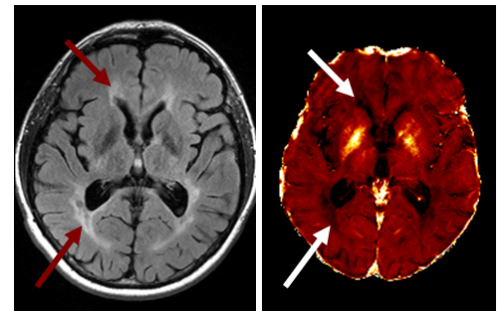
FLAIR image (left) and corresponding R2* map (right) of a 42 year old RRMS patient. Note the decreased intralesional R2* values (arrows).
